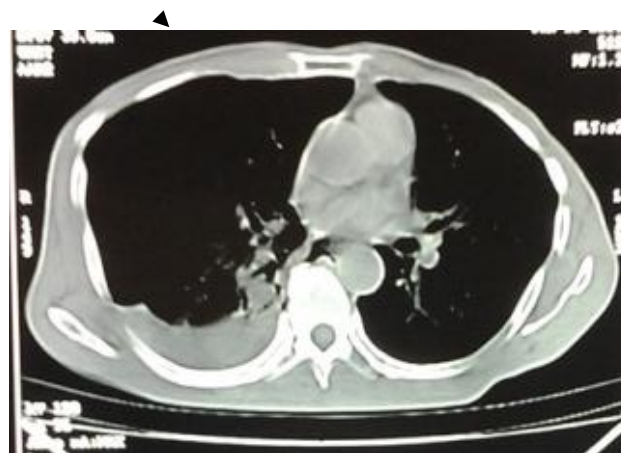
CT. thorax showing the hemothorax on the right side.
